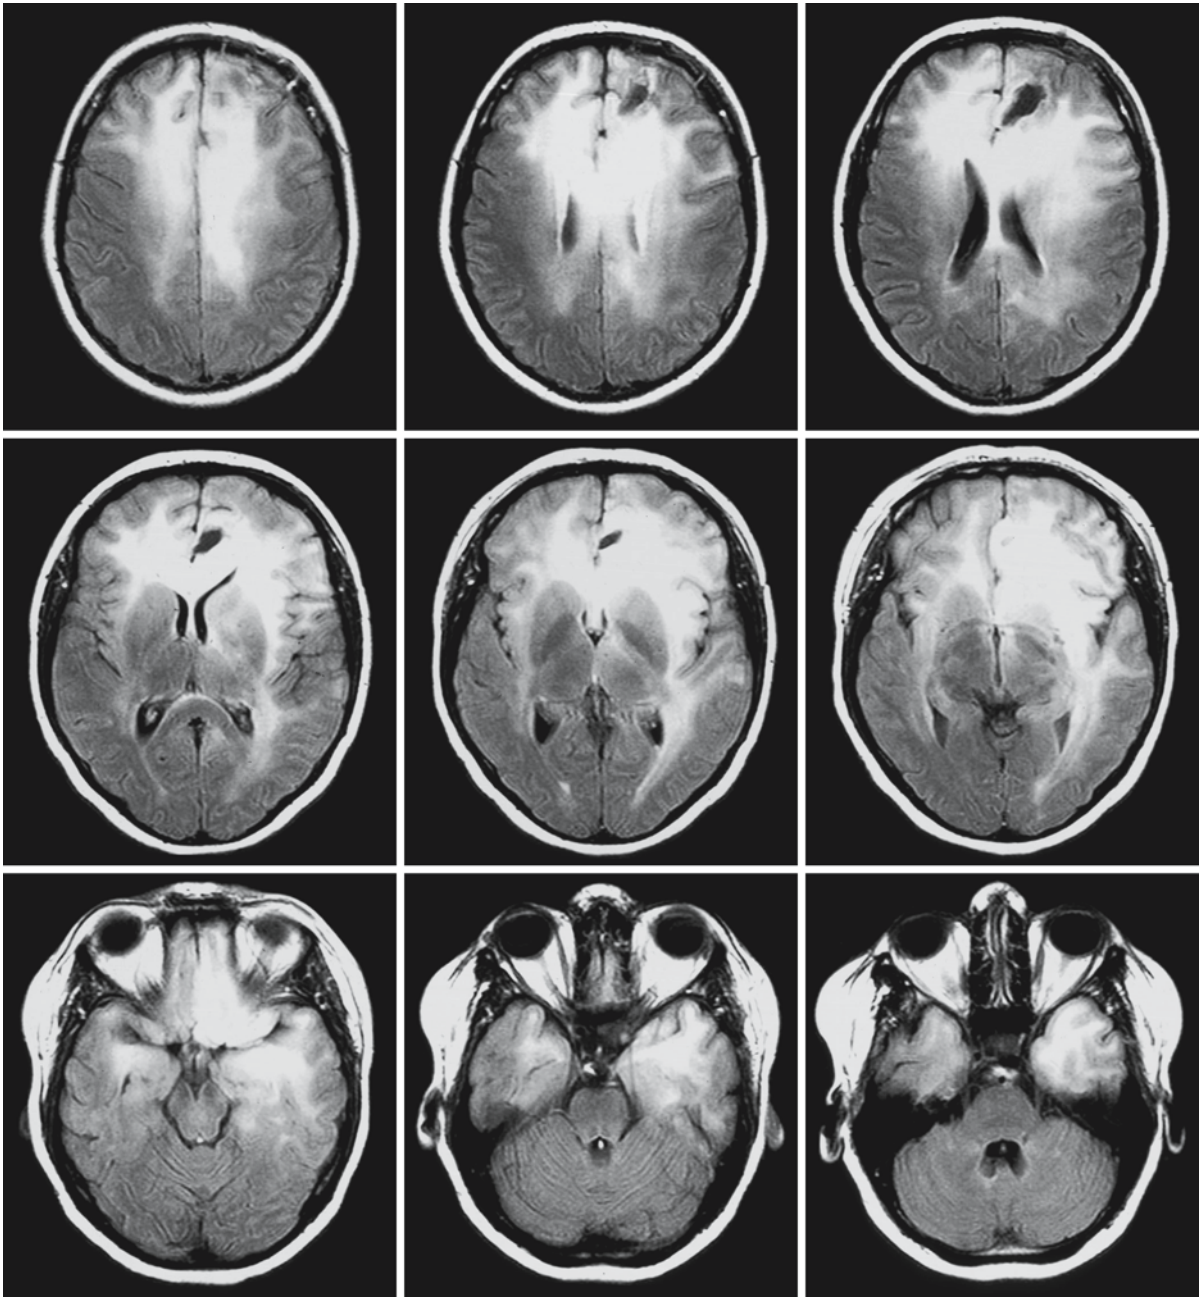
Series of FLAIR images in a 25-year-old man with biopsy-proven gliomatosis cerebri. The biopsy was taken from the left frontal lobe. In this case the abnormalities are mildly asymmetrical and have a prominent mass effect. There is clear
